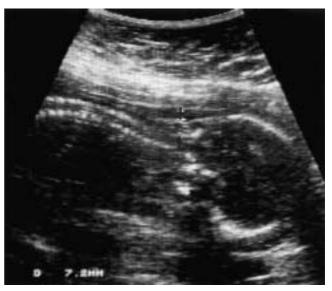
Longitudinal ultrasound image, showing nuchal thickening
